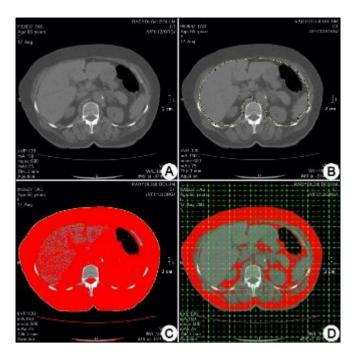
Usage of the ImageJ software for the estimation of volumes. A; an axial section of the abdominal CT, B; delineation of the innermost borders of the abdominal cavity, C; thresholding and semiautomatic delineation of the abdominal body region, D; superimposition of the point counting grid for the estimation of volume of visceral fat tissue
